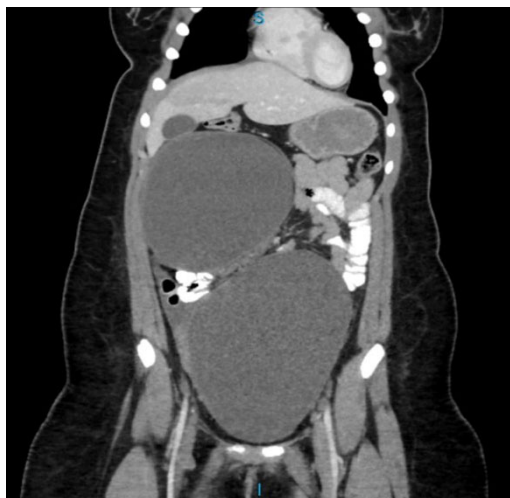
Coronal view of contrast enhanced (oral and intravenous) CT scan of abdomen and pelvis showing giant ovarian cysts.
